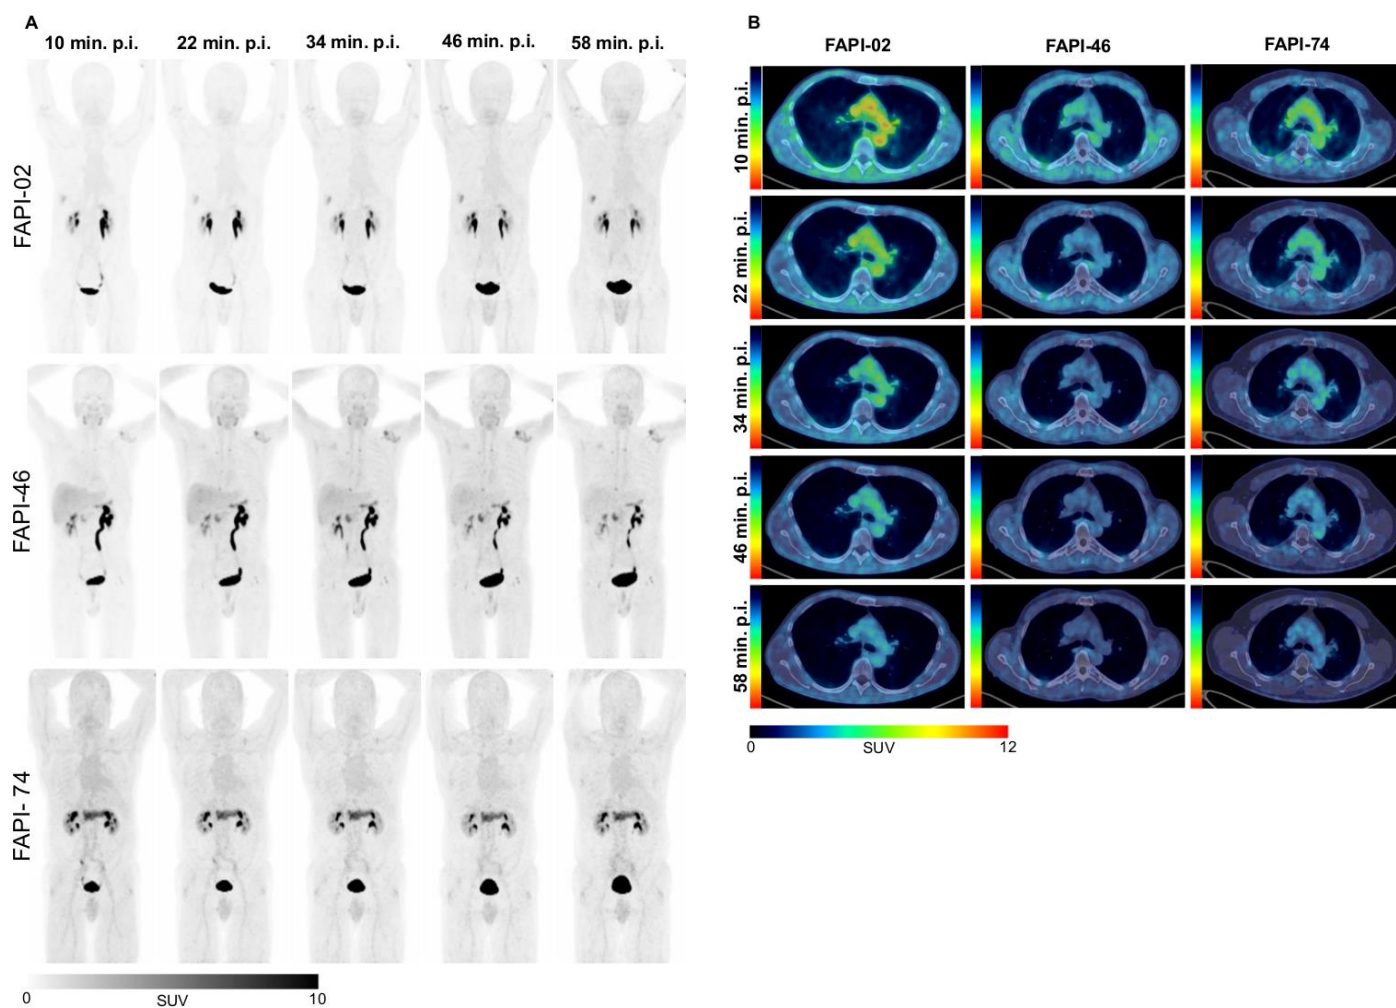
A Representative maximum injection projection (MIP) images of ^{68}Ga -FAPI-PET/CT imaging for FAPI-02 (upper row, 56 year old male patient with resected pancreatic carcinoma, staging for metastases, no local recurrence, single hepatic metastasis), FAPI-46 (middle row, 64 year old male patient with pancreatic cancer, staging with suspected local recurrence, no metastases) or FAPI-74 (lower row, 60 year old male patient with pancreatic carcinoma, staging in advance of radiation therapy, primary, single hepatic metastasis) over time with acquisition timepoints 10 min (1), 22 min (2), 34 min (3), 46 min (4) and 58 min (5) after application. B Representative axial fused ^{68}Ga -FAPI-PET/CT images of the upper thorax showing tracer uptake for blood, muscle and lungs over time with acquisition timepoints 10 min (1), 22 min (2), 34 min (3), 46 min (4) and 58 min (5) after application for FAPI-02 (left column, 56 year old male patient with resected pancreatic carcinoma, staging for metastases, no local recurrence, single hepatic
